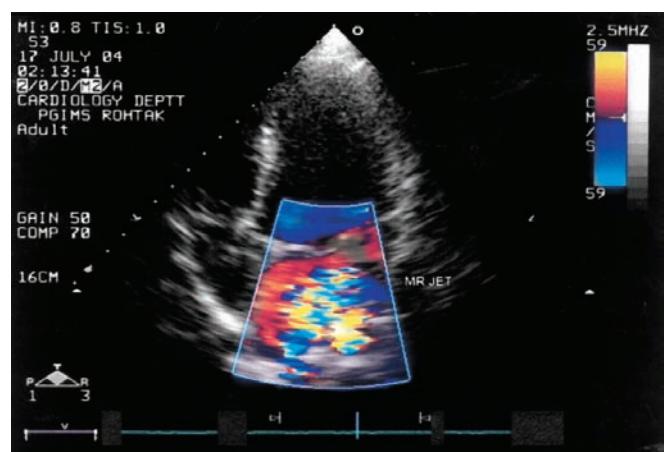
Colour Doppler study showing regurgitant jet across mitral valve in mitral regurgitation (MR)
